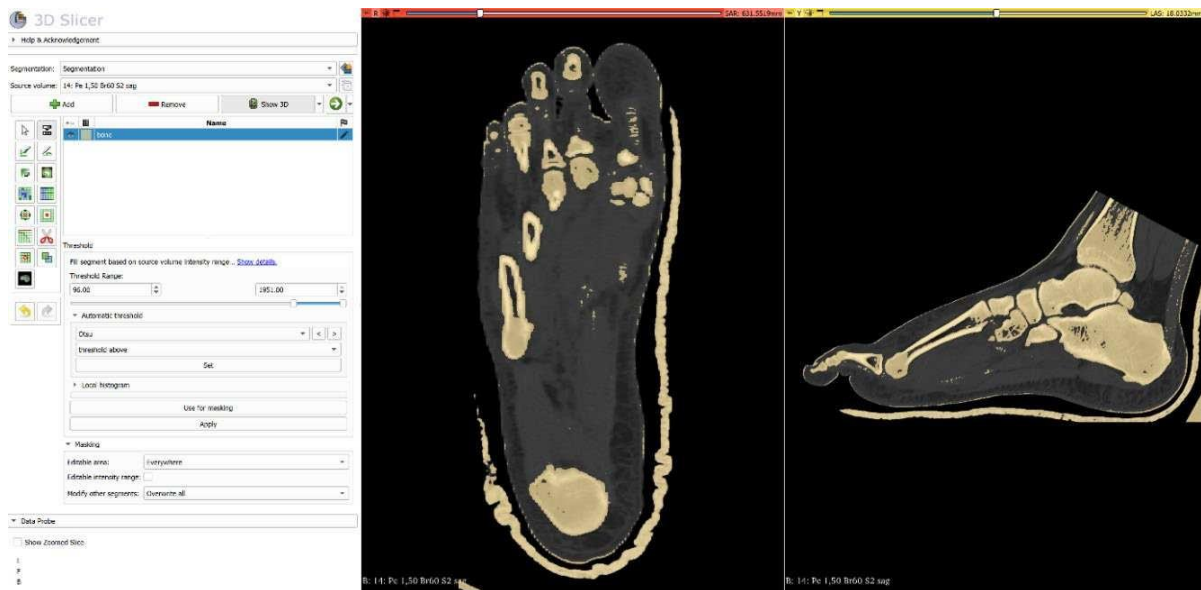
Visualization of using the Threshold tool in CT, in Slicer 3D®.
